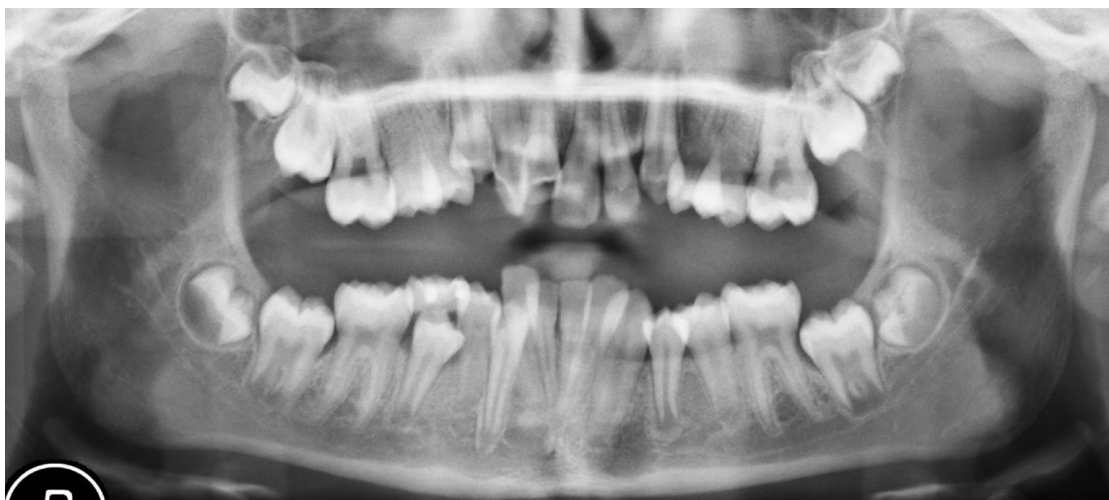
DPT radiograph showing “Stacked upper molars”
